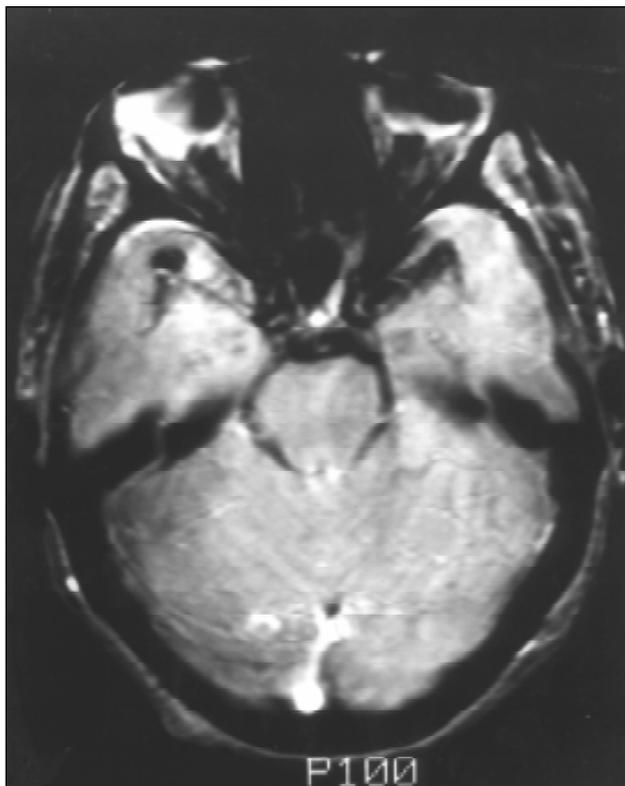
An MRI/MRA study demonstrated a 7 mm partially thrombosed middle cerebral artery bifurcation aneurysm on the right side.
